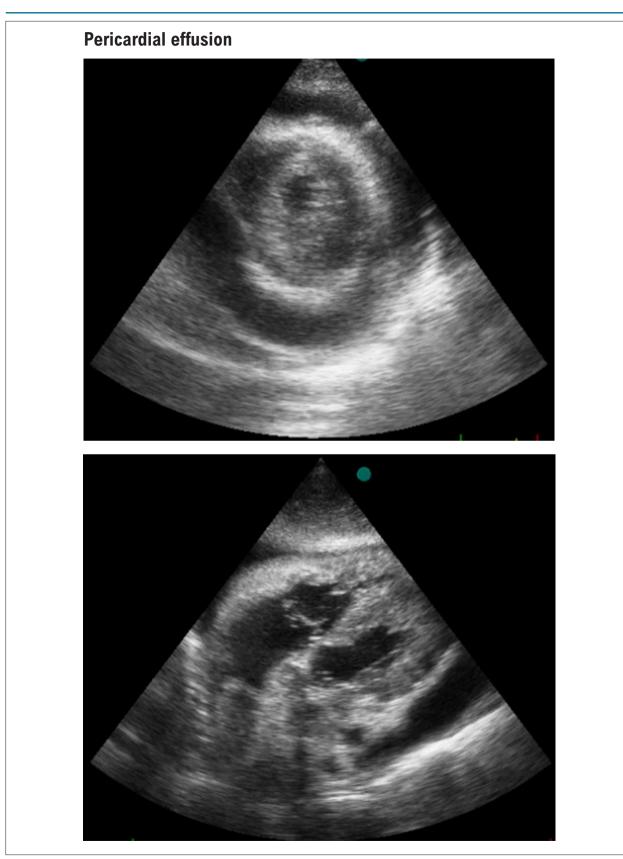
Massive pericardial effusion. A: fluid surrounding the entire heart seen on parasternal short-axis view. B: fluid surrounding the entire heart viewed through subcostal window.
